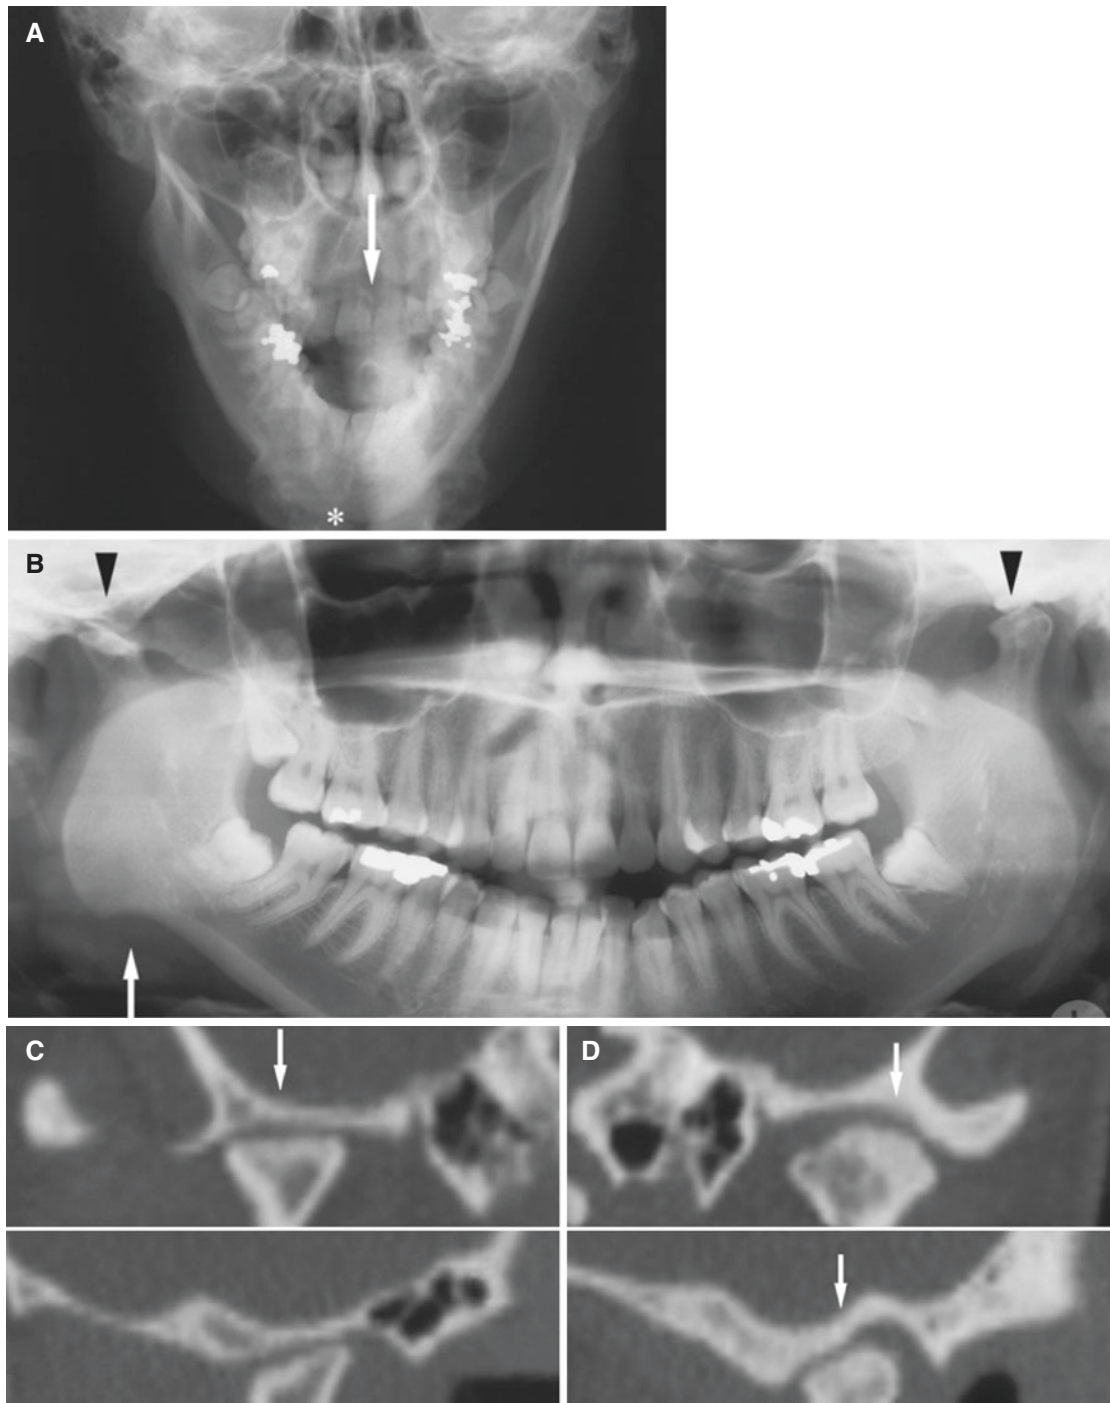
Retrognathia, slight micrognathia, and facial asymmetry; 35-year-old female with juvenile idiopathic arthritis from early childhood. (A) Posteroanterior view shows asymmetric mandible (*asterisk* midpoint of the chin) with deviation to the right side on the mouth opening (*arrow* midline of the maxilla). (B) Panoramic view shows mandibular asymmetry with most underdevelopment and antegonial notching (*arrow*) on the right side and bilateral condyle abnormalities (*arrowheads*) with most severe abnormalities of the right joint. (C) CT
